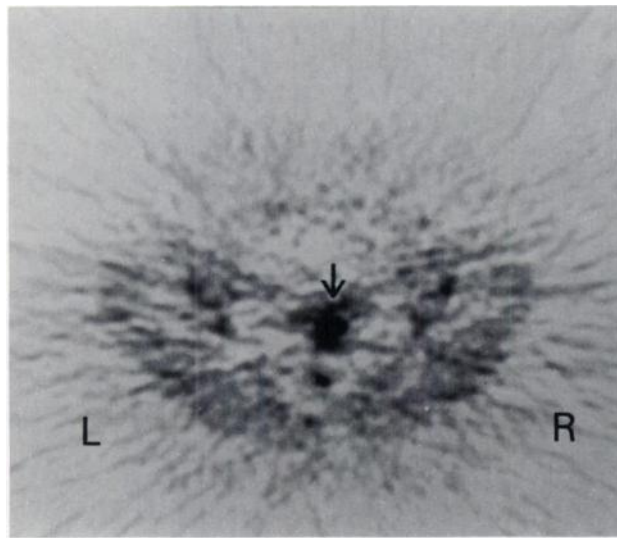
Carbon-11-methionine PET image of a patient with endometrial adenocarcinoma (arrow) Stage IA (Patient 8, Tables 1 and 2). The SUV of the tumor is 8.6, and the K_i value is 0.09. The small hot spot posterior to the uterine lesion is the bowel.
